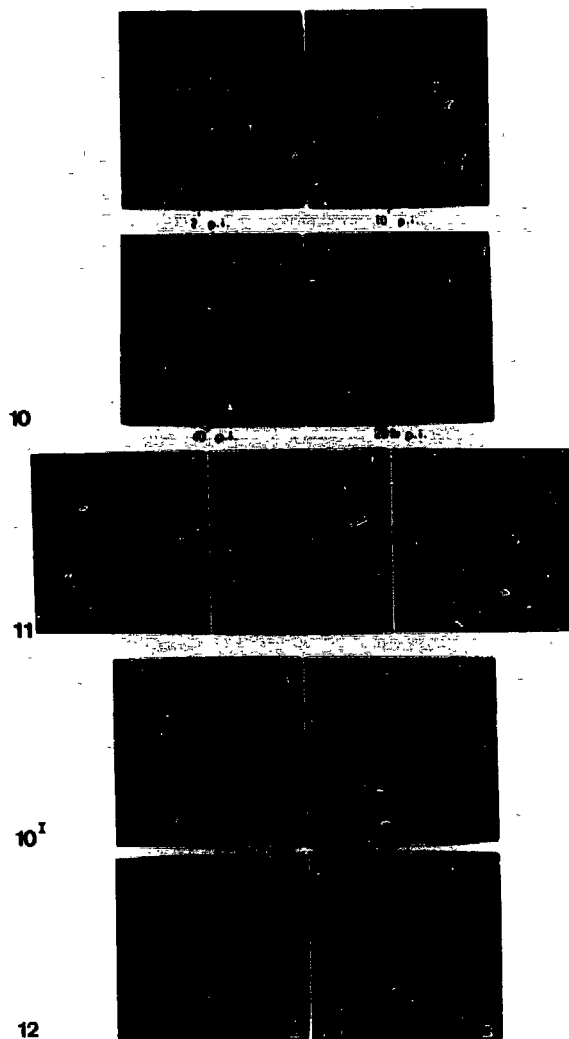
10-12 Cholescintigraphy in a patient with a malignant obstructive process in liver hilus.
